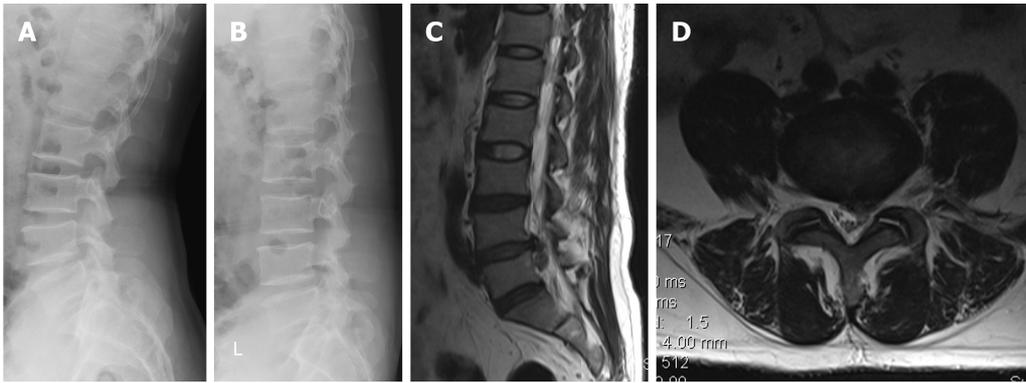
Preoperative imaging assessment. A and B: Preoperative extension-flexion radiographs suggested decreased height without instability in the disc space (L4-5); C and D: Magnetic resonance imaging confirmed L3-S1 disc degeneration with associated low signal intensity and lumbar disc herniation (L4-5) on T2-weighted and axial images.
